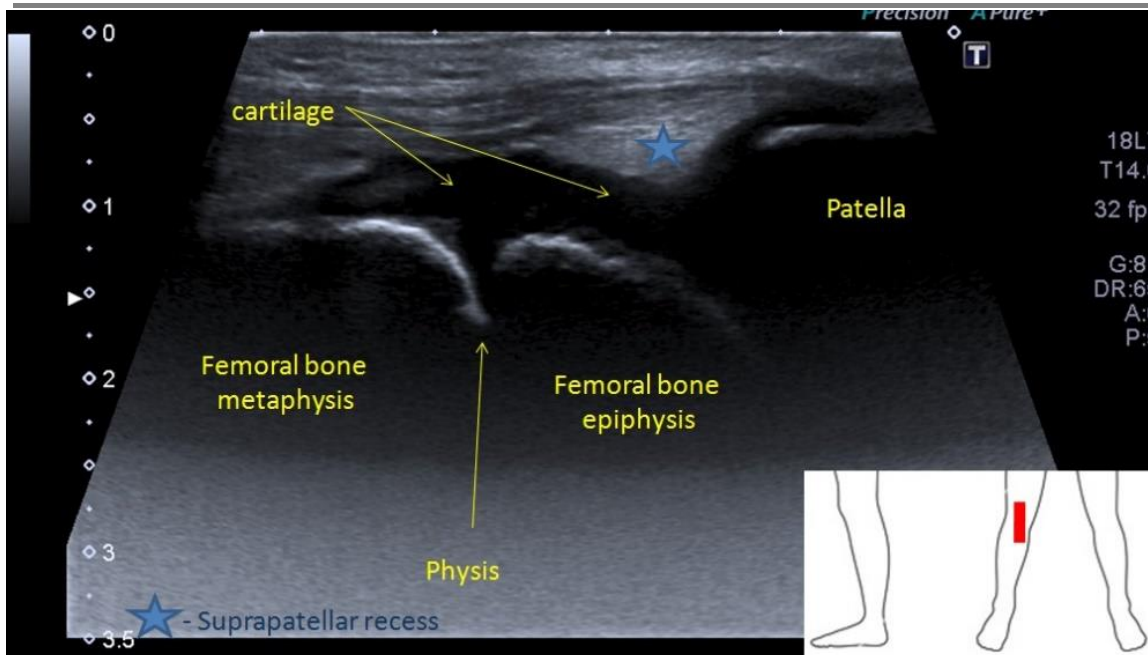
Knee ultrasound demonstrating normal pediatric knee anatomy. This linear probe image confirms the presence of the open physis (growth plate) separating the femoral metaphysis and epiphysis. The hypoechoic layer of cartilage and the A/P depth in the suprapatellar recess (blue star) are crucial for assessing joint integrity and effusion.
